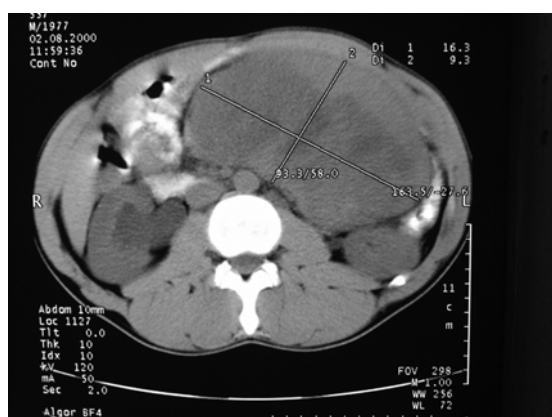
CT scan on a large intraabdominal desmoid tumour in a 24 year old FAP male patient, which occurred 1 year after prophylactic subtotal colectomy.
